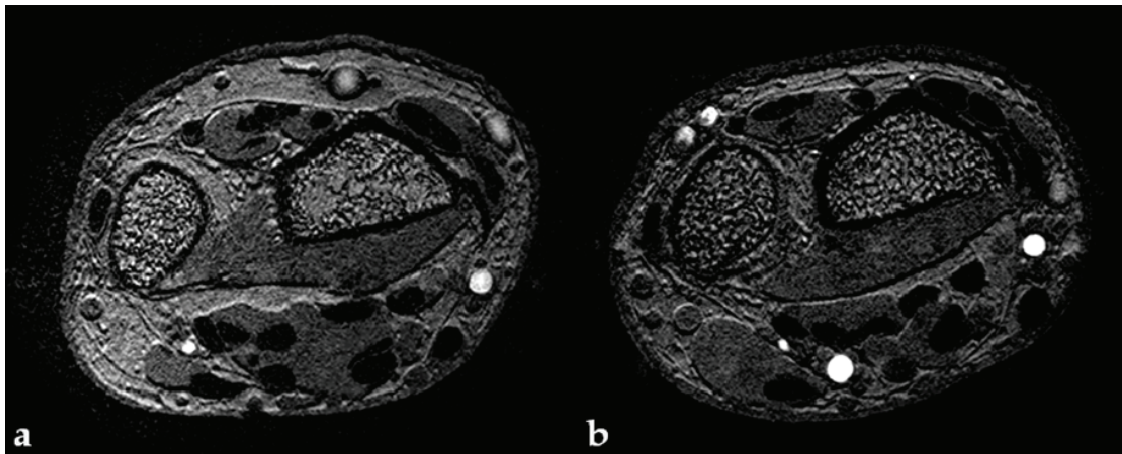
Images acquired with a 3 Tesla MRI system (Achieva, Philips Healthcare, Best, The Netherlands). In a), wrist slice corresponding to the acquisition performed in a left-handed 62 years old female patient with osteoporosis. In b), image corresponding to a series acquired in a left-handed 64 years old female healthy volunteer.
